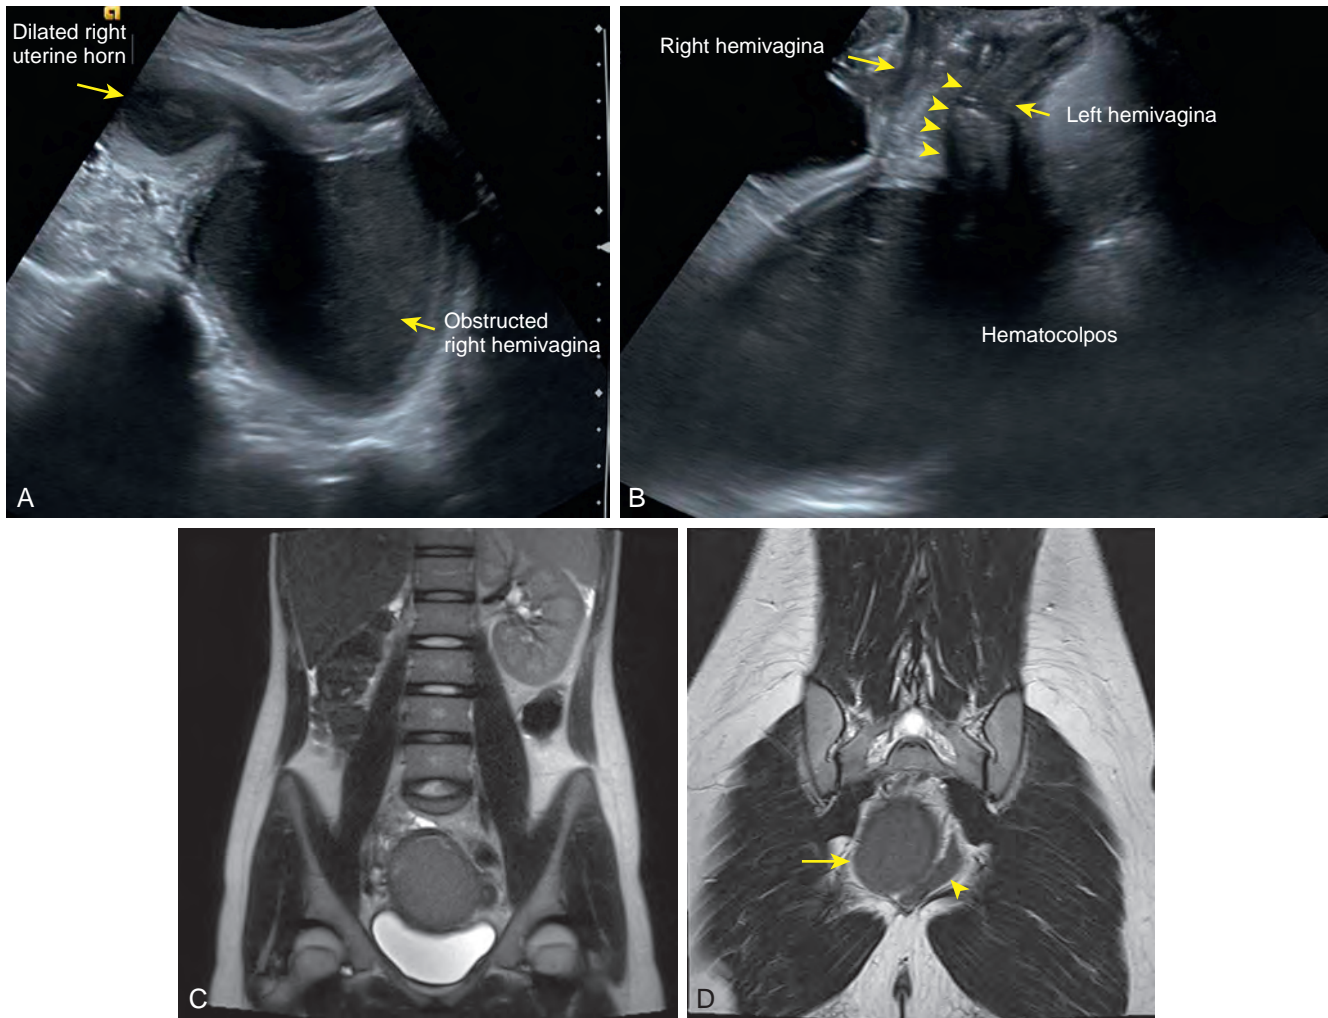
Fourteen-year-old girl with pelvic pain underwent a pelvic sonogram that shows (A) sagittal view of right hemipelvis with dilated uterine horn (arrow) and obstructed hemivagina (arrow). B, Translabial view of right hemipelvis and normal left hemivagina. A longitudinal vaginal septum is observed (arrowheads). C, Magnetic resonance imaging demonstrates coronal T2 image of right renal agenesis with bowel occupying the right renal fossa and hematocolpos. D, Coronal T2 image of right hemipelvis (arrow) and normal left hemivagina (arrowhead).
